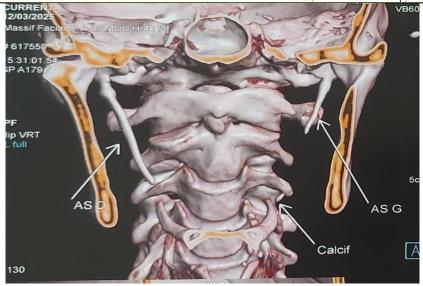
Cervical CT scan with 3D reconstruction showing elongation of both styloid processes composed of a single fragment extending toward the lesser horn of the hyoid bone, indicating ossification of the stylohyoid ligament
